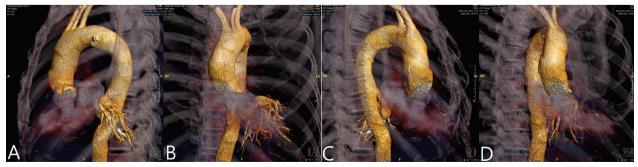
Computed tomography angiography 3D-image vascular reconstruction showed an accessory artery rising from the descending thoracic aorta and then dividing toward the left lower lung lobe. Is there some description for the A,B,C, and D images?????
